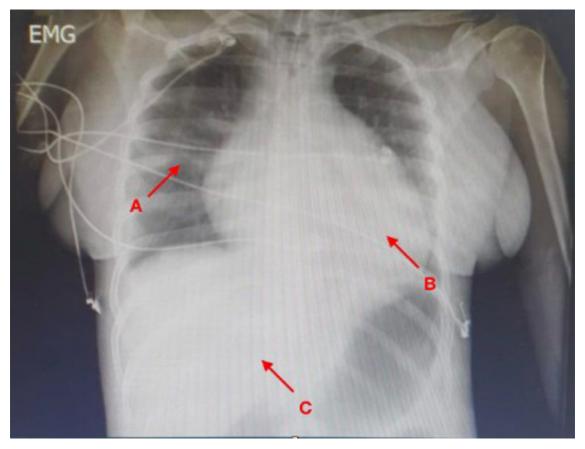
Posteroanterior chest X-ray showing straightening of the costal arches (A), cardiomegaly (B) and hepatomegaly (C).
